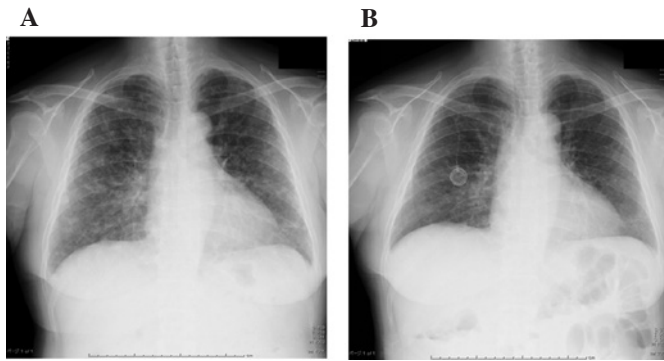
Chest X-ray showing (A) numerous granular shadows in both lung fields prior to chemotherapy. (B) Disappearance or size reduction in some granular shadows was observed following chemotherapy.
